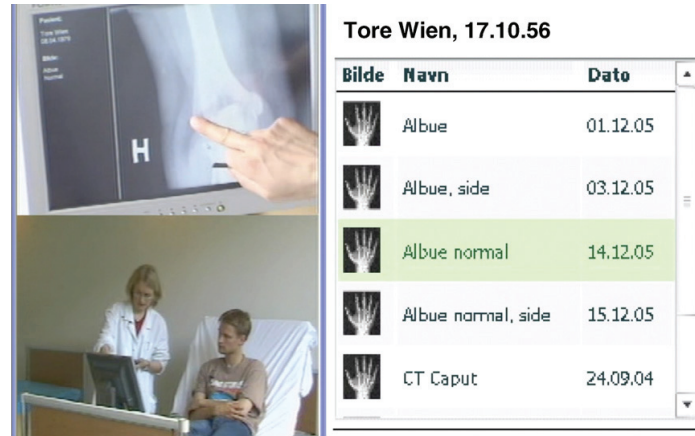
The physician uses her PDA to select an X-ray image to show to the patient.
